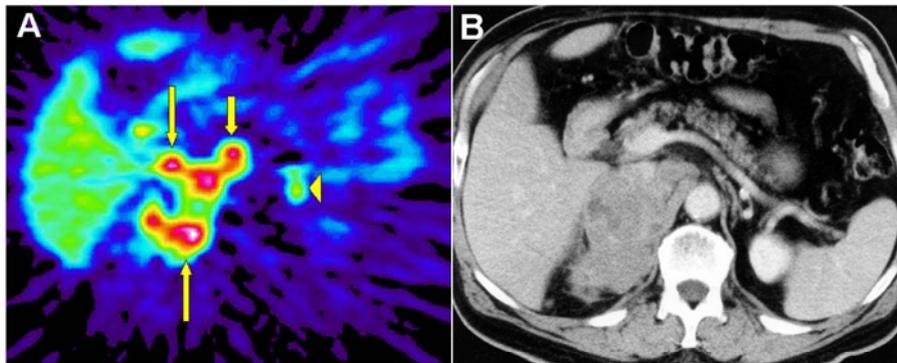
(A) ^{11}C -metomidate PET image; a patient with a right-sided primary tumor (*long arrows*), a lymph node metastasis (*short arrow*) and a normal left adrenal (*arrowhead*). (B) The corresponding CT image; the large heterogeneously contrast-enhancing right adrenal tumor is seen to have a necrotic centre.
